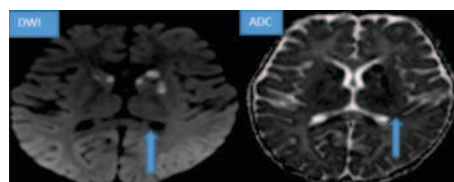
Bilateral basal ganglia hyperintensities showing restricted diffusion on DWI/ADC sequences in a case hypoxic ischaemic encephalopathy in a term infant.
